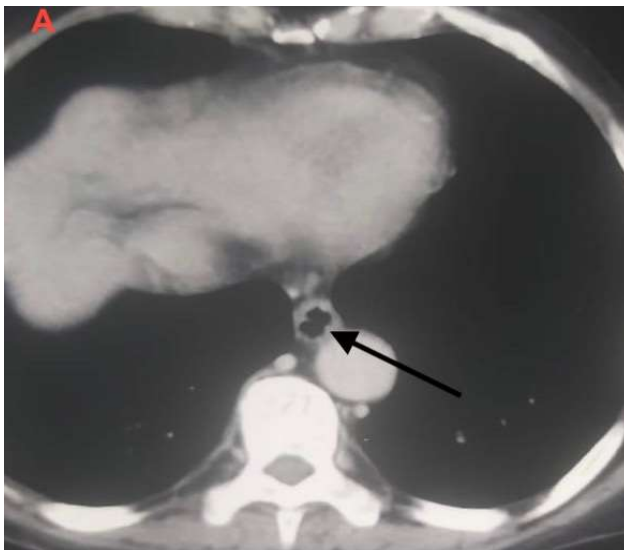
65 years old male patient with known liver cirrhosis on routine endoscopic evaluation. CT: axial cut of triphasic study portal phase showed low-risk varices score 1 measures about 0.6 mm(black arrow image A). Endoscopy findings: grade 1 esophageal varices (white arrows, image B).
